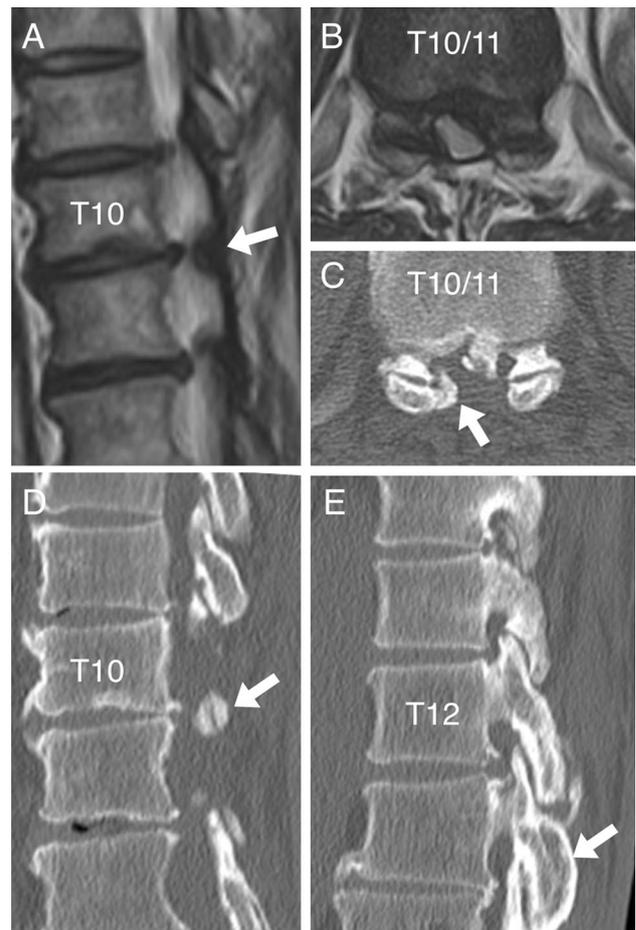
Case 2. MR images and CT scans obtained before the second operation. Sagittal (a) and axial (b) T2-weighted images show the compressed spinal cord at the T10–11 intervertebral level (arrow in a). Axial (c) and sagittal reconstruction (d) CT scans show the OLF markedly re-extended on the right side at the T10–11 levels (arrows in c and d). Additionally, a sagittal reconstruction (e) CT scan shows the facet joints are fused below the T12–L1 level (arrow in e)
